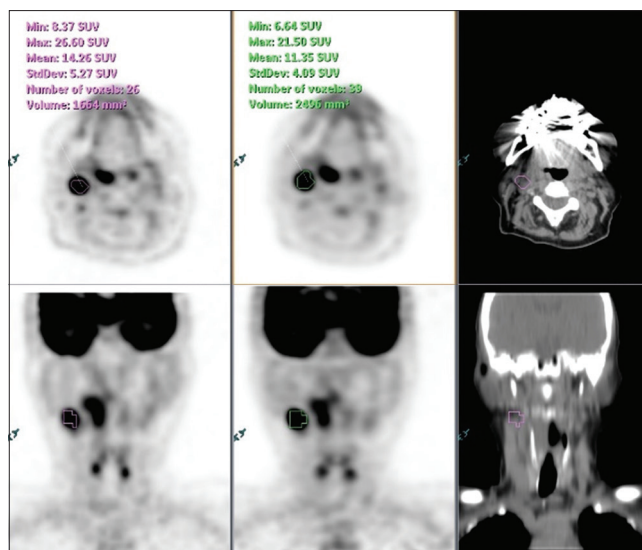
A 67-year-old woman with biopsy-proven squamous cell carcinoma of the right tonsil for staging. Axial and coronal A-positron emission tomography images (left) showed a volume of 2496 mm<sup>3</sup> at 35% standard uptake value threshold and D-positron emission tomography images (middle) showed a volume of 1664 mm<sup>3</sup> for the right Level II cervical lymph node, representing a -33.3% volume reduction at D-positron emission tomography; corresponding computed tomography images (right). Standard uptake value gradient was 8.3 at A-positron emission tomography and 11.1 at D-positron emission tomography, corresponding to a 33.7% increase in sharpness at D-positron emission tomography
